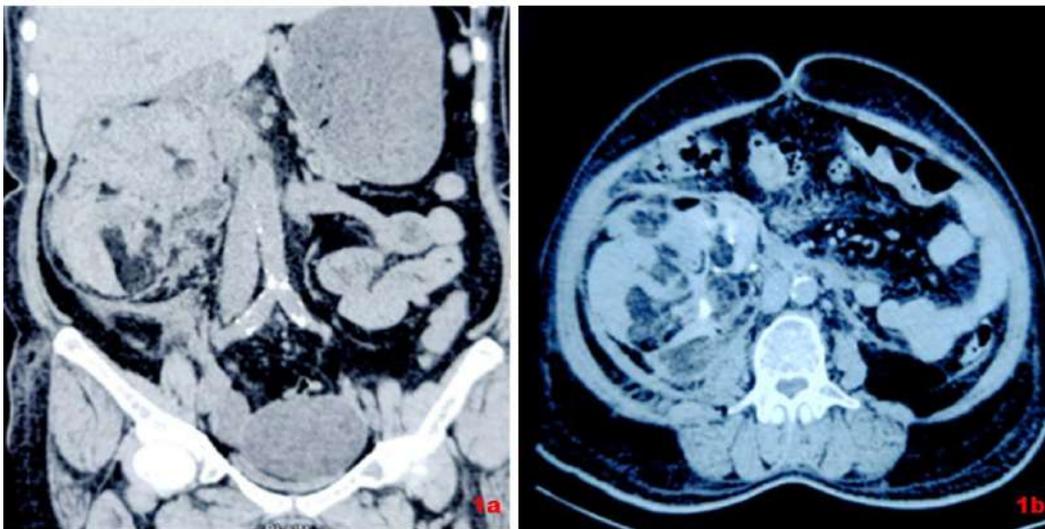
Computed tomography (CT) showing a Right kidney replaced by heterogeneously enhancing ill defined mixed density area of fat and blood with perinephric oedema and ill-defined hypo and hyperdense collections. The extension of collection was into peri-nephric region, retroperitoneum, right para-colic gutter, supra-renal and hepato-renal pouch
